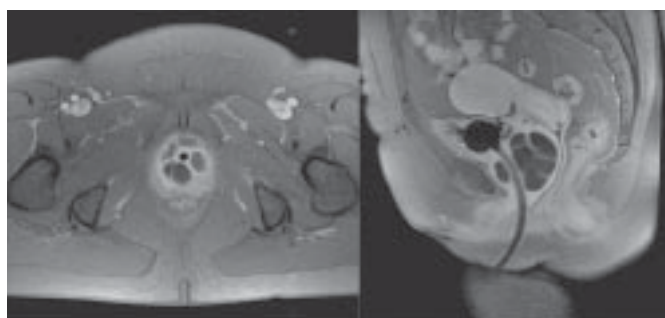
Magnetic resonance imaging with a T1 FLASH 2-D sequence protocol. A circumferential urethral diverticulum is noted.
